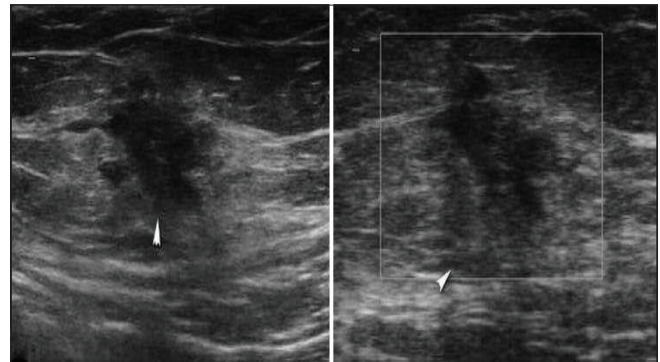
High-resolution sonogram shows heterogenous solid mass in a post-operative case of TAH and BSO
